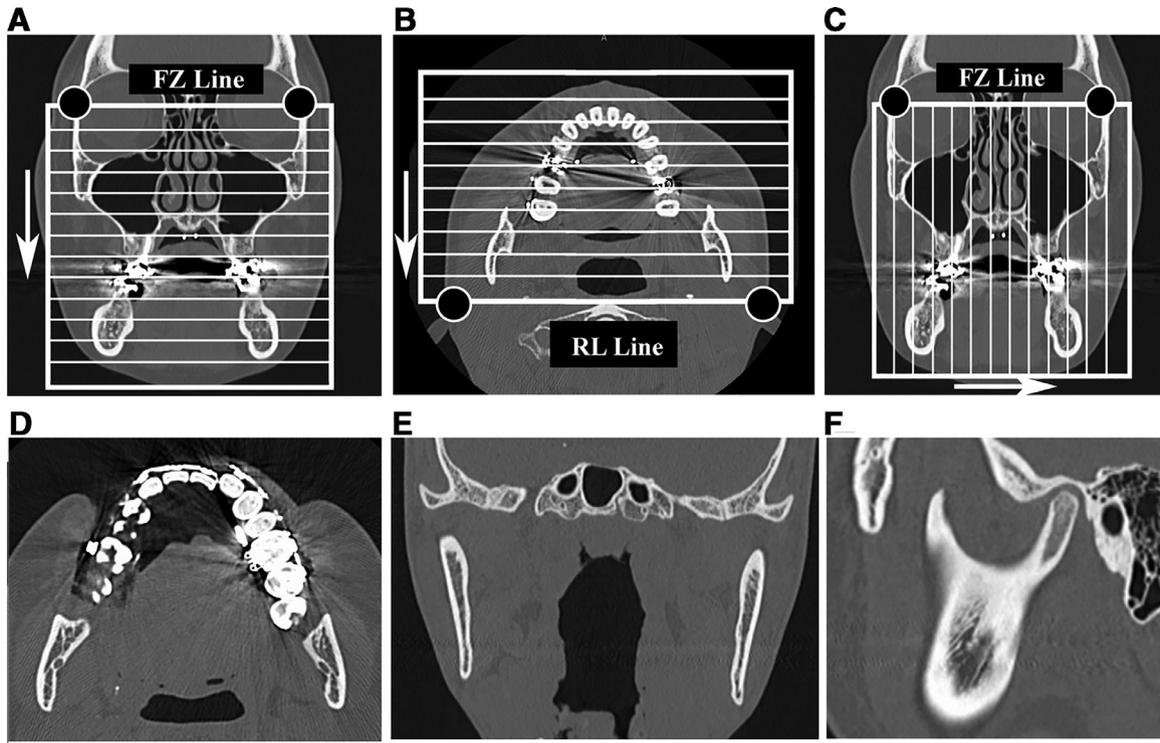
Method of measuring 3-dimensional quantitative color mapping created by using computed tomography (CT) data. The frontozygomatic line (FZ line) was defined as the line between the most lateral points of the bilateral frontozygomatic sutures (A,C).The right and left side lines (RL line) was defined as the line between the most anterior points of the bilateral auricles (B). A-C, On the basis of the reference point, 3-dimensional data were reconstructed with 2-mm-width slice imaging by multiplanar reconstruction. (D) We drew a line tangent to the bilateral foramen-mandibular posterior region and measured the posterior areas. (E) We extracted only the part of the mandibular bone that contained the cleavage. (F) We determined reference points of Porion (Po), crest of articular eminence (CAE). We drew the vertical line of Po-CAE line, which passed through the top of the coronoid process and measured the posterior areas.
